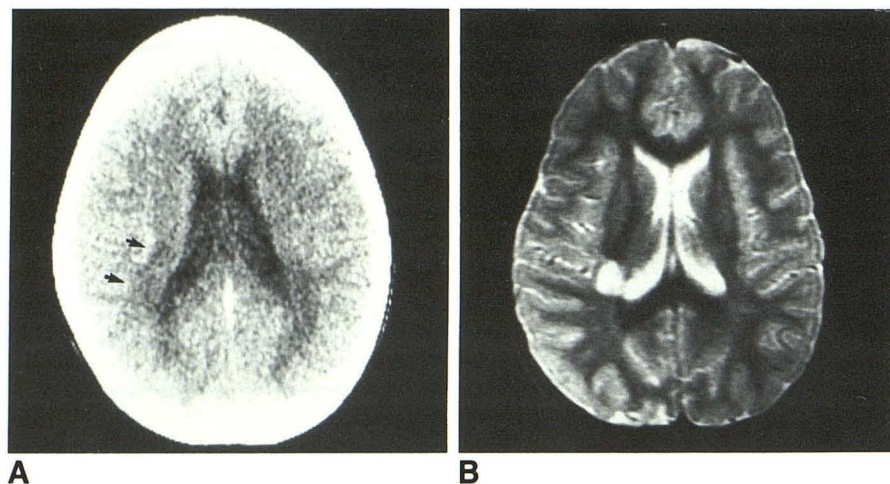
A, Contrast-enhanced CT scan suggests focal hypodensity in peritriangular centrum semiovale on the right in 5-year-old boy who presented with a history consistent with acute disseminated encephalomyelitis (arrows).
